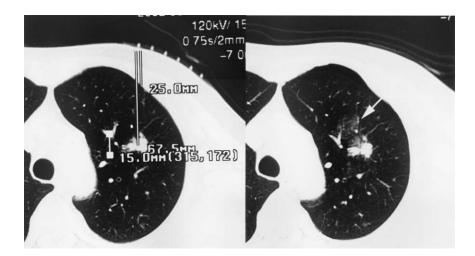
The scanner projected 6 parallel grids onto the skin as landmarks to determine the site for needle insertion. The distance from the skin to the pleura or to the tumor was measured *(left)*. After achievement of local anesthesia, technetium 99m tin colloid was injected in the vicinity of the lesion with a 22-gauge needle. Subsequently, the location of the injected technetium *(arrow)* and the lesion were confirmed by means of CT *(right)*. Injected radioisotope was confirmed as an area of ground-glass attenuation near the tumor.
